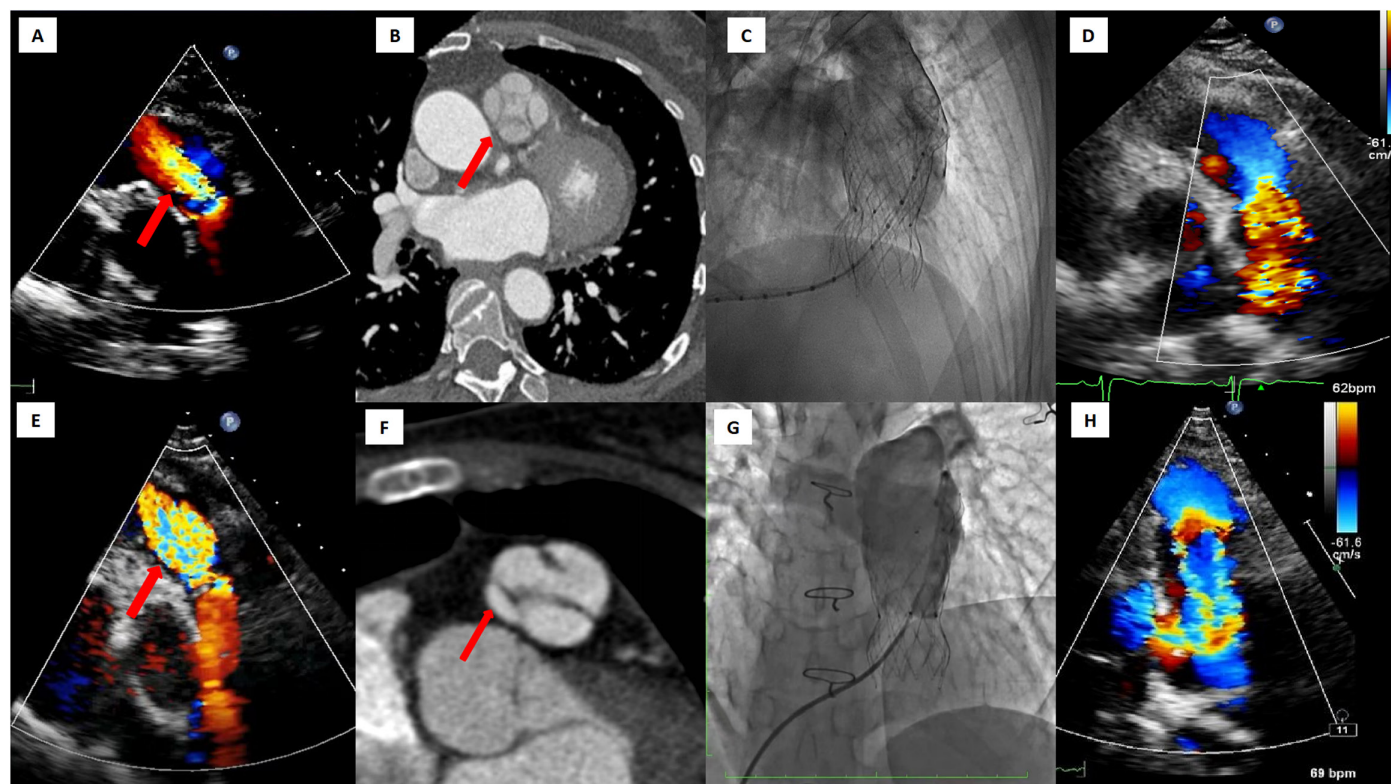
Case 1. (A) Transthoracic echocardiogram (TTE) shows severe pulmonary valve regurgitation. (B) Reconstructed Computed tomography (CT) angiography shows a quadricuspid pulmonary valve with 4 symmetrical cusps (arrow). (C, D) The result of transcatheter pulmonary valve implantation with no pulmonary regurgitation. Case 2. (E) Transthoracic echocardiogram shows severe pulmonary valve regurgitation. (F) Reconstructed CT angiography shows a quadricuspid pulmonary valve with 1 rudimentary cusp (arrow). (G, H) The result of transcatheter pulmonary valve implantation with no pulmonary regurgitation.
